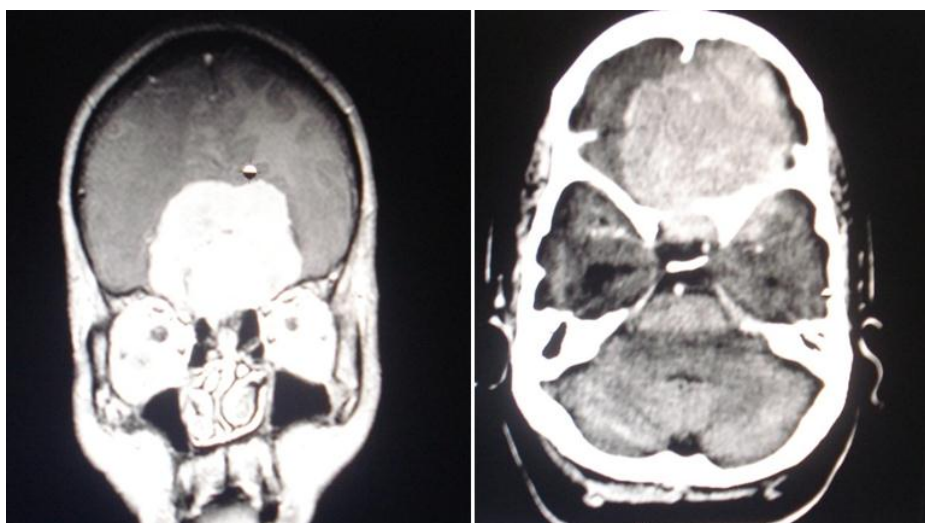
Showing MRI and axial CT Contrast of patient showing large olfactory groove meningioma respectively.
